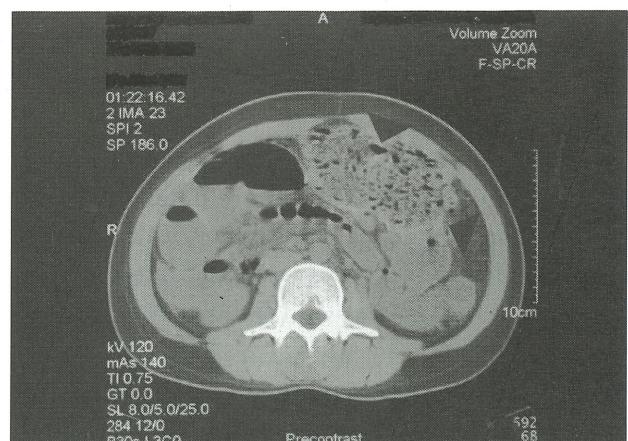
Computed tomography of abdomen showed well-defined outline of a mixed density mass with multiple air bubble in mid part of abdomen (arrow).
